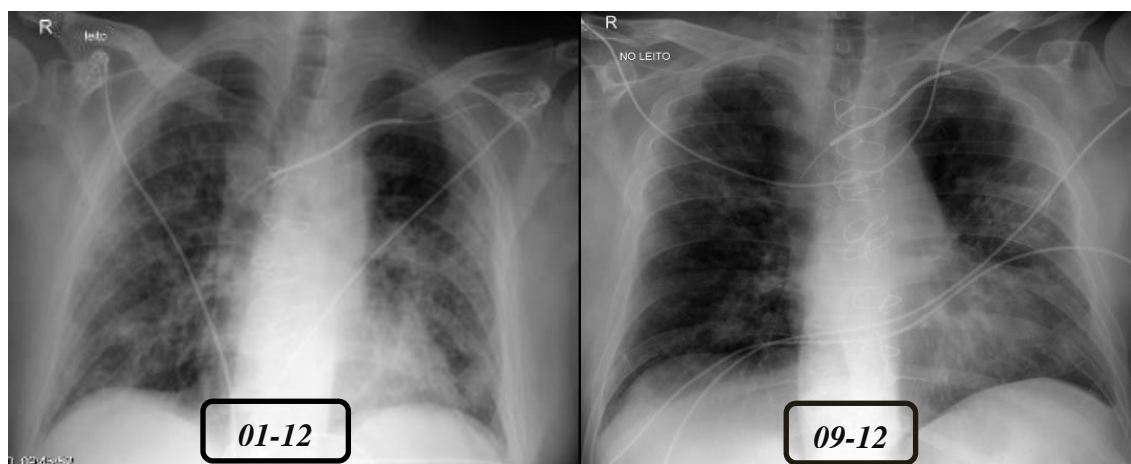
Thoracic X-ray comparison.
